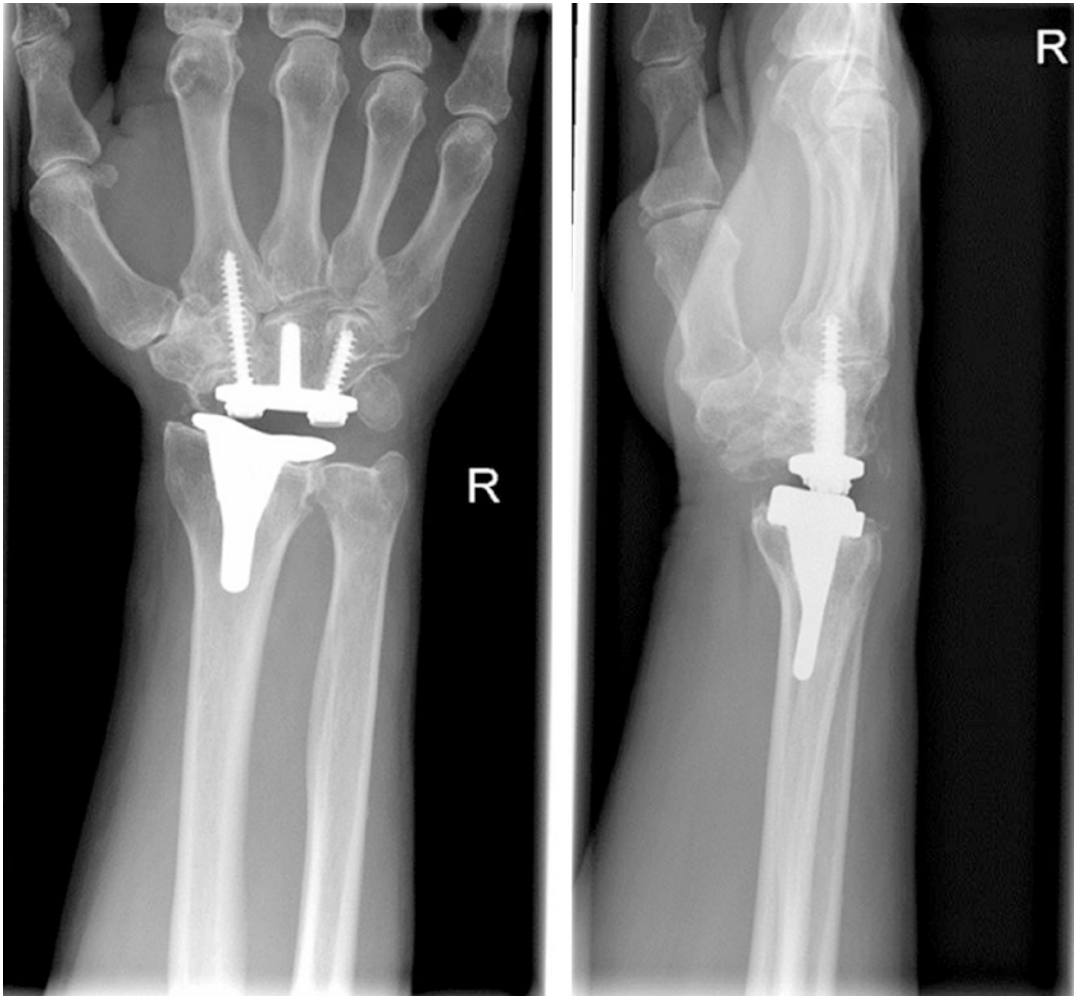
Radiograph of a total wrist arthroplasty using the Freedom Total Wrist Implant System. Images courtesy of Mr. K. O'Shea, National Orthopaedic Hospital, Cappagh, Dublin
